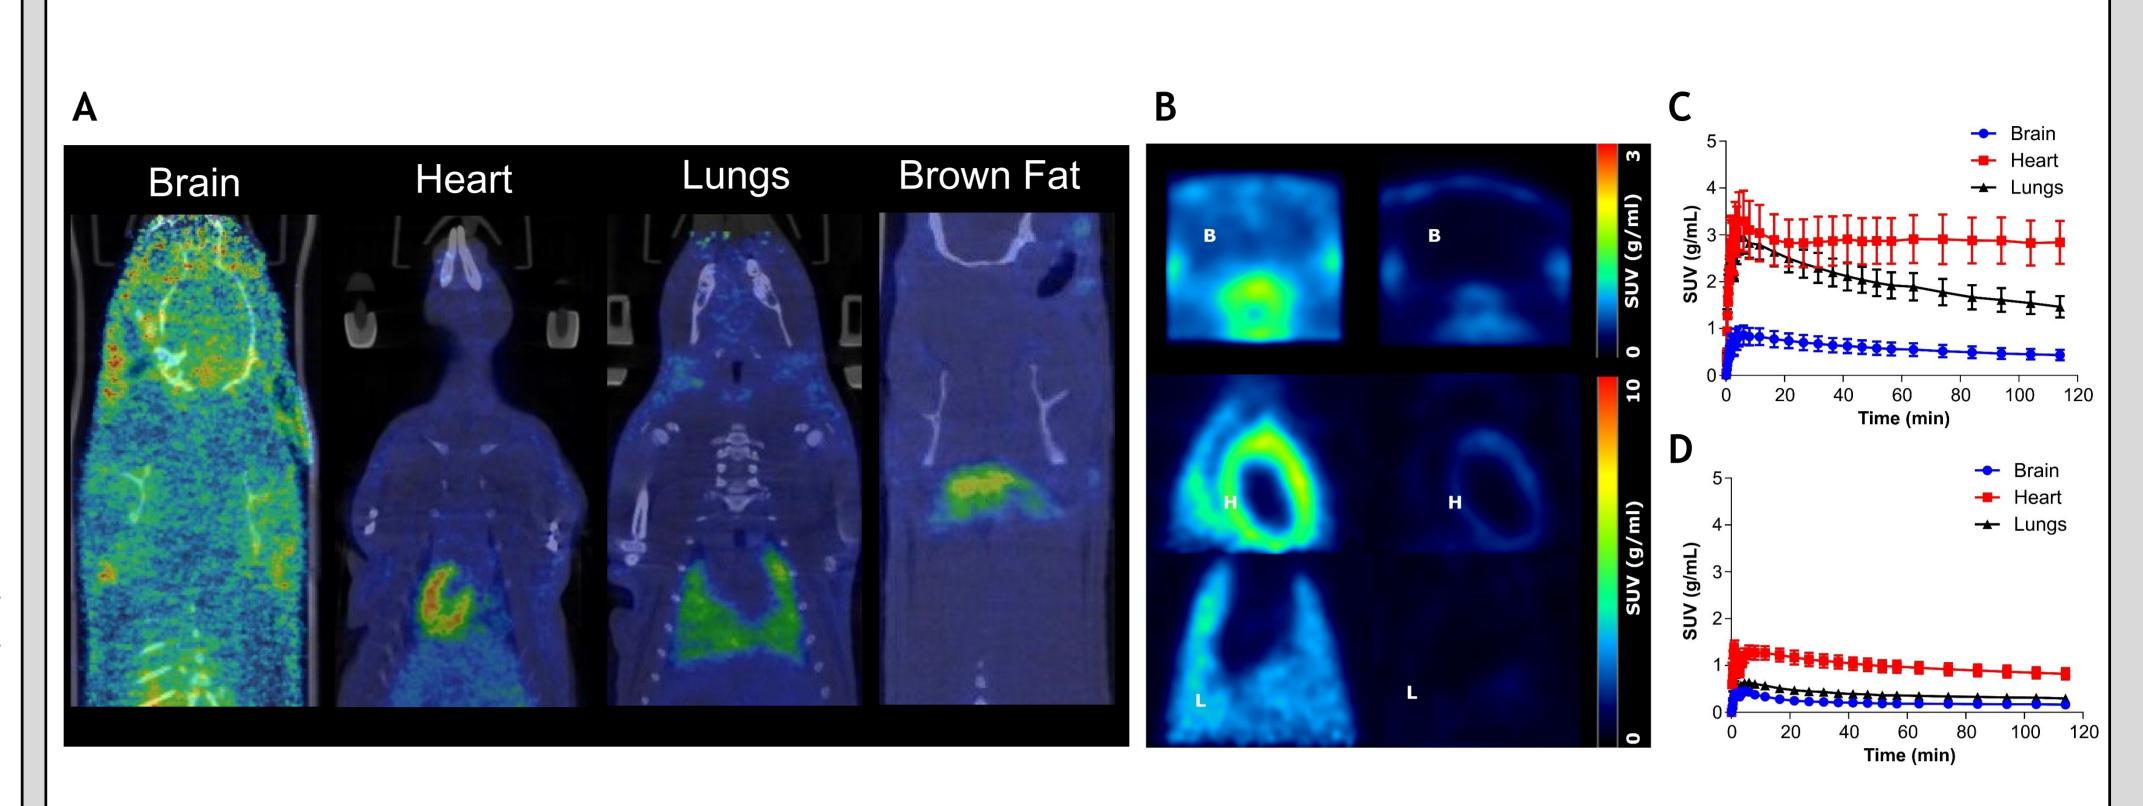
A) The in vivo distribution of ¹⁸F-LW223. B) SUV sum images of ¹⁸F-LW223 uptake before and after administered of PK11195 (1 mg/kg). C) Time activity curves for the major source organs at baseline and D) following PK11195 blockade. Results represent the mean ±SEM, n=3. Legend: B=brain, H=heart and L=lungs.
